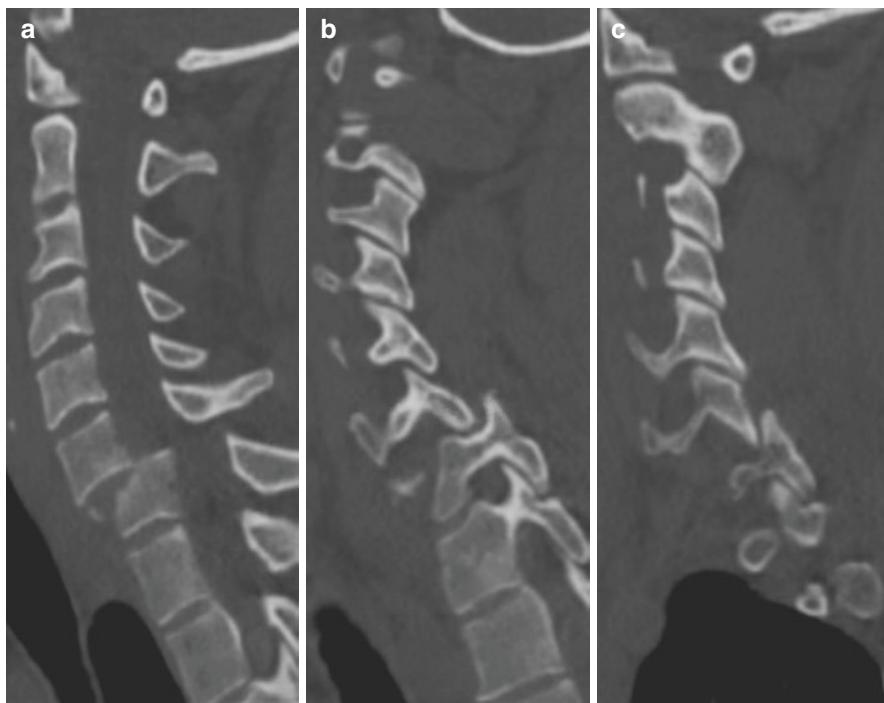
(a–c) Cervical CT showing bilateral jumped facets. (a) Sagittal midline view showing anterolisthesis of C6 over C7; (b) sagittal view of left-sided jumped facet at C6/C7; (c) sagittal view of right-sided jumped facet at C6/C7
